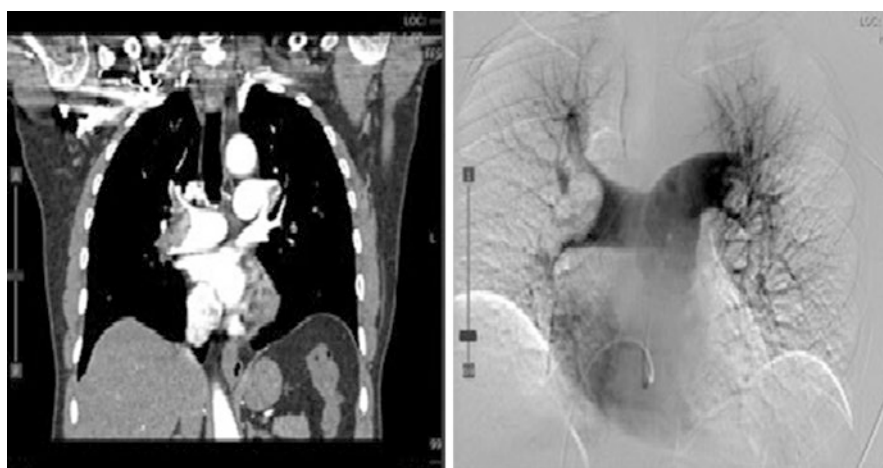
CTA showing large filling defects in the distal aspects of the right and left main pulmonary arteries consistent with bilateral acute pulmonary emboli. Mild dilatation of the main pulmonary artery
